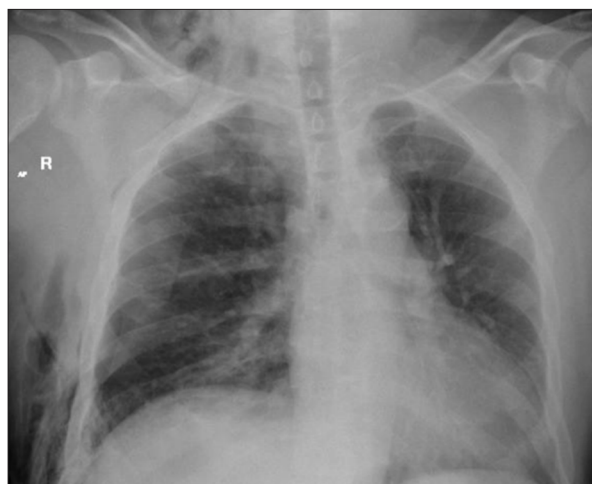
Initial chest X-ray following patient admission to the Emergency Department. Anteroposterior chest X-ray at admission showing a small right pneumothorax. Associated ill-defined opacities in the right lung base consistent with pulmonary contusions are seen. There is also abundant subcutaneous emphysema along the lateral chest wall of the right hemithorax, with underlying multiple rib fractures. No definite evidence of intercostal lung herniation is apparent.
